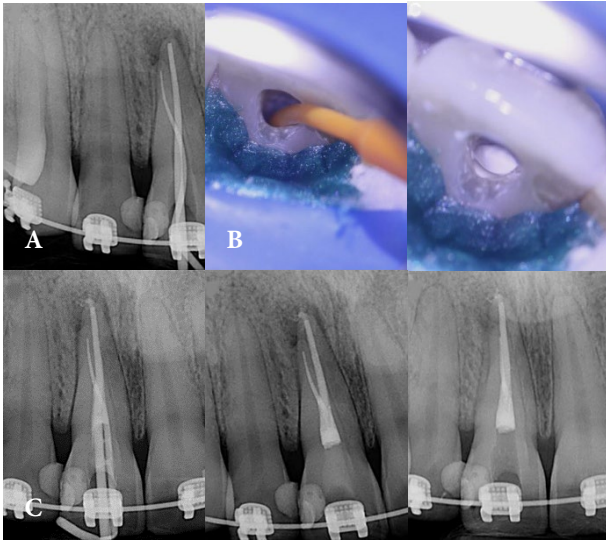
A) Master gutta-percha cones test; B) Insertion of bioceramic sealer and its appearance after its placement in the root canals; C) Post-operative periapical radiographs with different angulations showing the quality of obturation of the root canals
